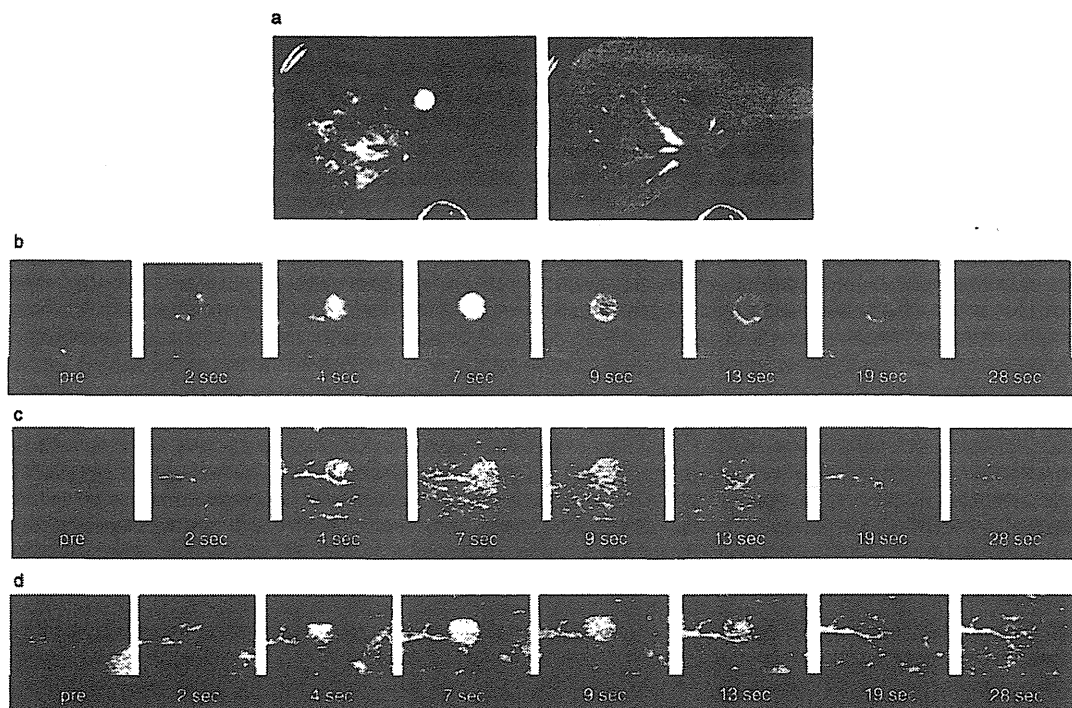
A 69-year-old female with recurrence of HCC 1.5 cm in diameter in segment 2. (a) CTHA (left) and CTAP images. Tumor was enhanced on CTHA and showed a flawed image on CTAP. (b) Images of the tumor on single-level dynamic CTHA, which was performed just before and 2, 4, 7, 9, 13, 19 and 28 s after injection of contrast material from the common hepatic artery. (c) Images of the tumor on USHA at the same times before and after injection of contrast material in the same manner as for CTHA. (d) Images of the tumor on ordinary contrasted US obtained at the same times as for CTHA and USHA after the beginning of the enhancement procedure. (b–d) Slightly larger area became enhanced in 7–13 s after the start of enhancement. Enhancement of the real tumor area became faint and corona enhancement became visible as seen in (b) and (c) but not in (d). CTAP, computed tomography during arterial portography; CTHA, computed tomography during hepatic arteriography; HCC, hepatocellular carcinoma; USHA ultrasonography during hepatic arteriography.
